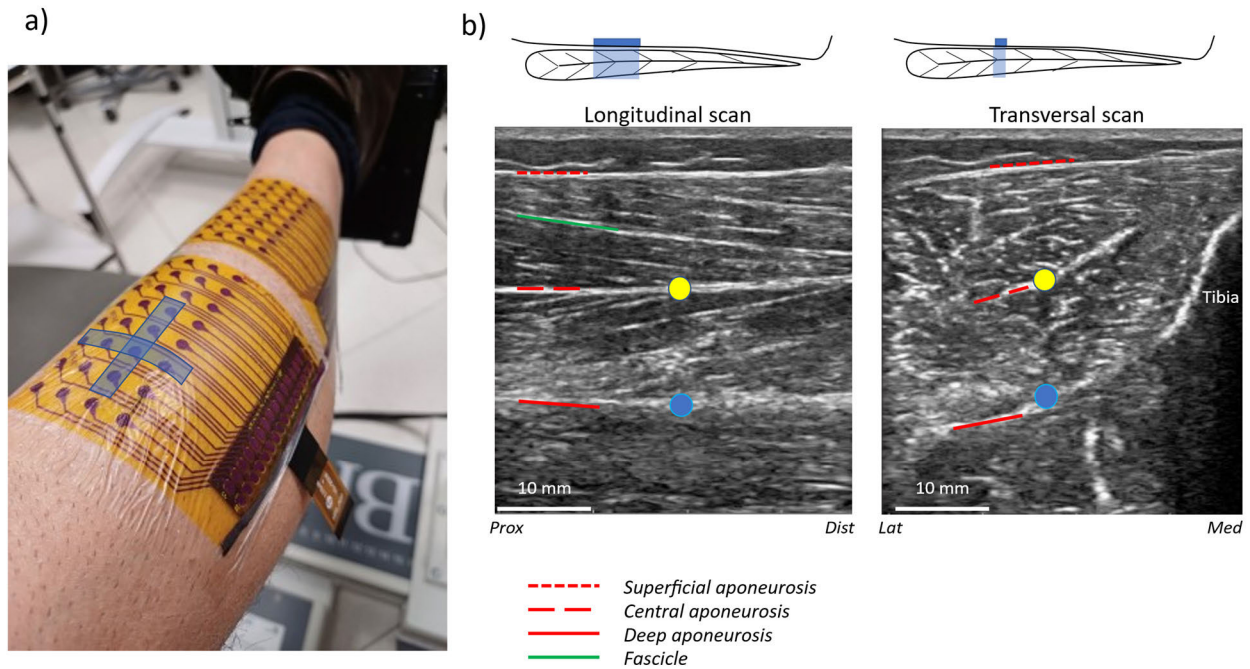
Ultrasound images of the longitudinal and transverse sections of the tibialis anterior were obtained by placing the ultrasound probe on the surface of ReGrid. The position of the ultrasound probe is indicated with two blue rectangles on the left picture. Anatomical muscle structures, such as muscle fascicles and aponeuroses, are clearly visible in both ultrasound images.
